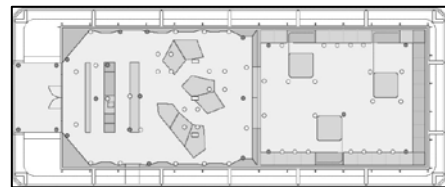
Positions of the 70+ ultrasound receivers in the iHomeLab. The inner grey rectangle indicates the covered area (about 300 m²). The iHomeLab is located at Lucerne University of Applied Sciences at the Horw Campus.
